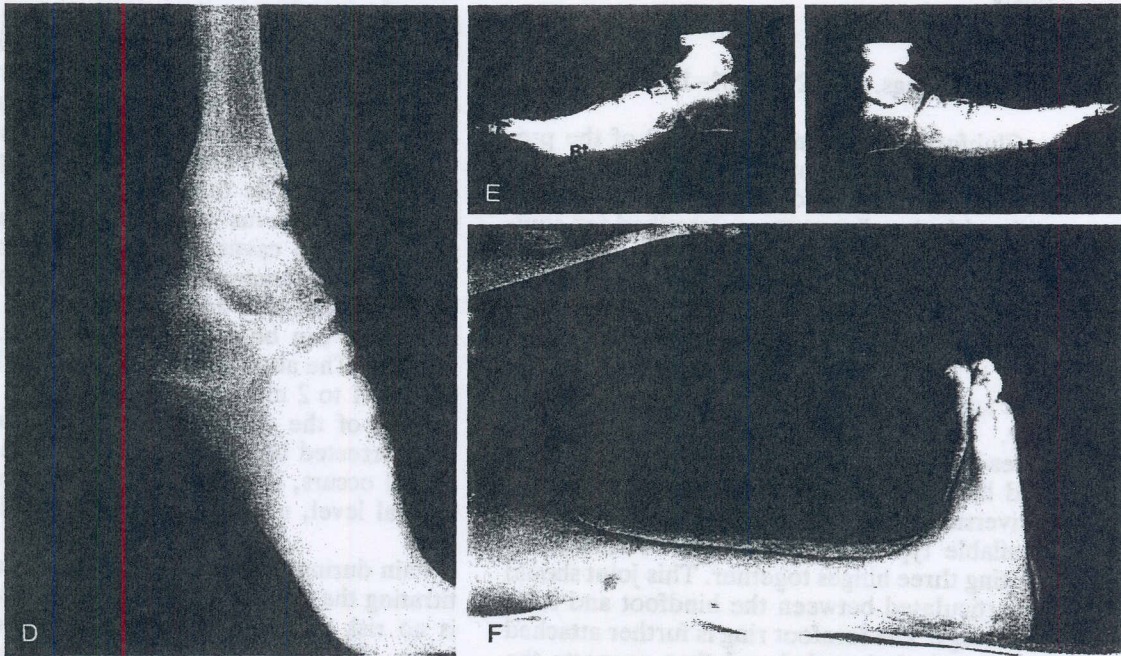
Continued (D), A lateral standing radiograph of the foot before the correction. (E), Radiographs of both feet at the end of the correction. Note the overcorrection achieved in the flattening of the arch on one of the sides, with plantar subluxation of the talonavicular joint on the left (Lt). One wire was placed in each navicular to act as a fulcrum for the correction. (F), The final clinical appearance shows no equinus or cavus deformity.
